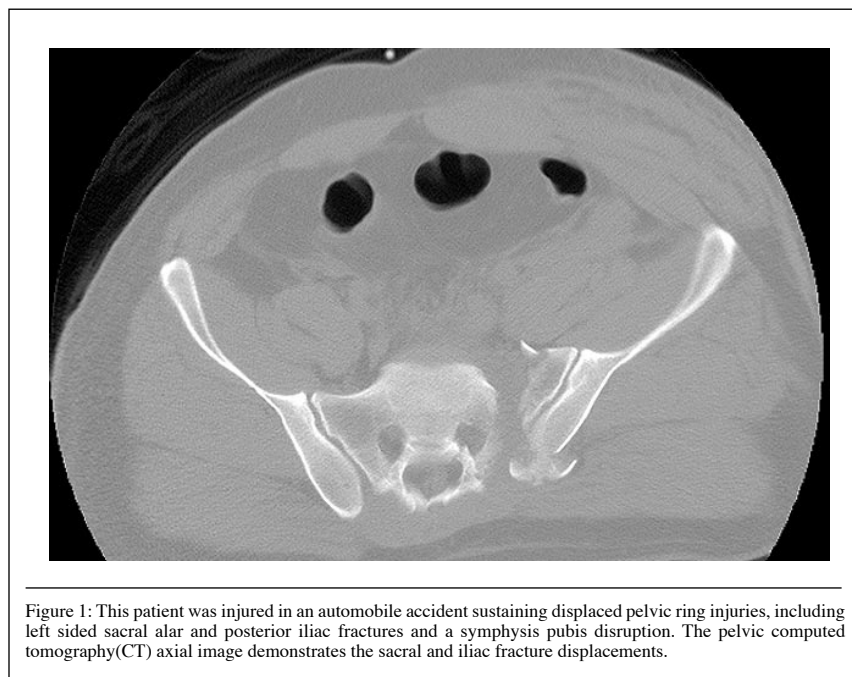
This patient was injured in an automobile accident sustaining displaced pelvic ring injuries, including left sided sacral alar and posterior iliac fractures and a symphysis pubis disruption. The pelvic computed tomography(CT) axial image demonstrates the sacral and iliac fracture displacements.
